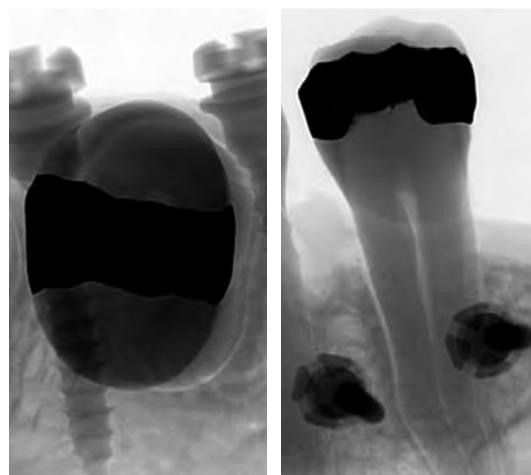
Interradicular X-ray image showing spatial ratios.
